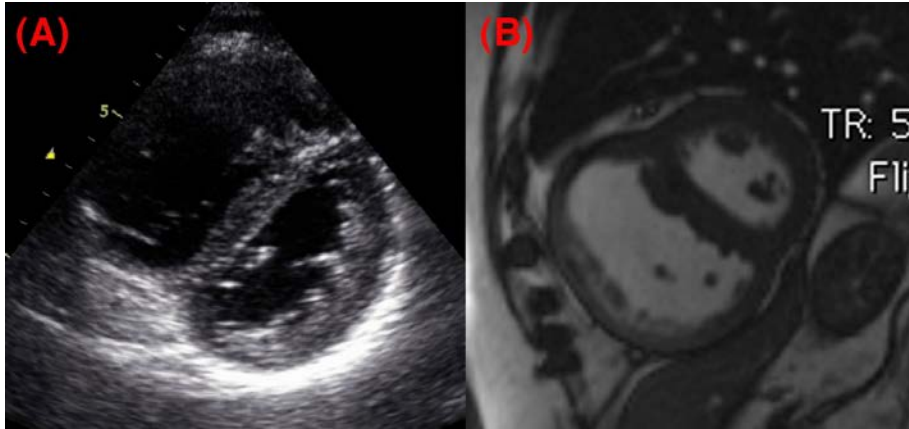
RV volume overload and “D” shaped flattening of the interventricular septum affecting LV filling. (A) parasternal short axis echocardiography view of the volume overloaded RV (left) causing D-shaped flattening of the interventricular septum and reversal of the transeptal gradient with resultant underfilling of the LV cavity (right). (B) Corresponding steady state free precession short axis cine CMR image demonstrating the same pathophysiology.
